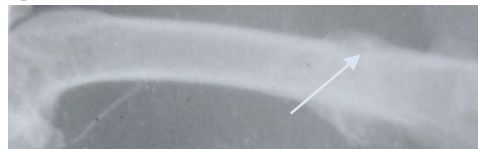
Radiographic image end of tenth week p. o. increase of cortex at the fracture site gray arrow.
